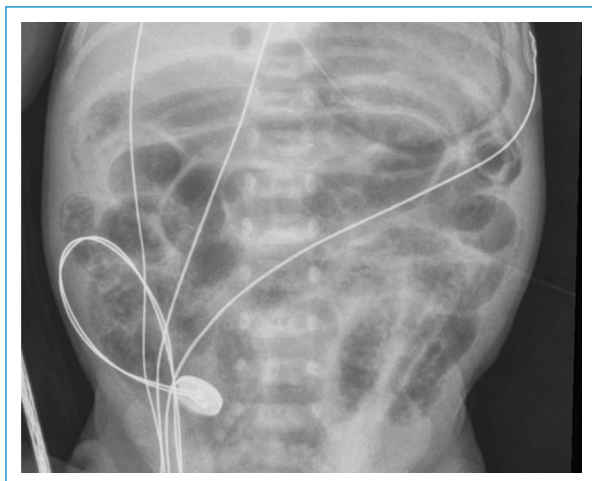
X-ray of the abdomen showing gastric and intestinal pneumatosis of linear appearance, intestinal pneumatosis of cystic appearance, as well as pneumoperitoneum.
